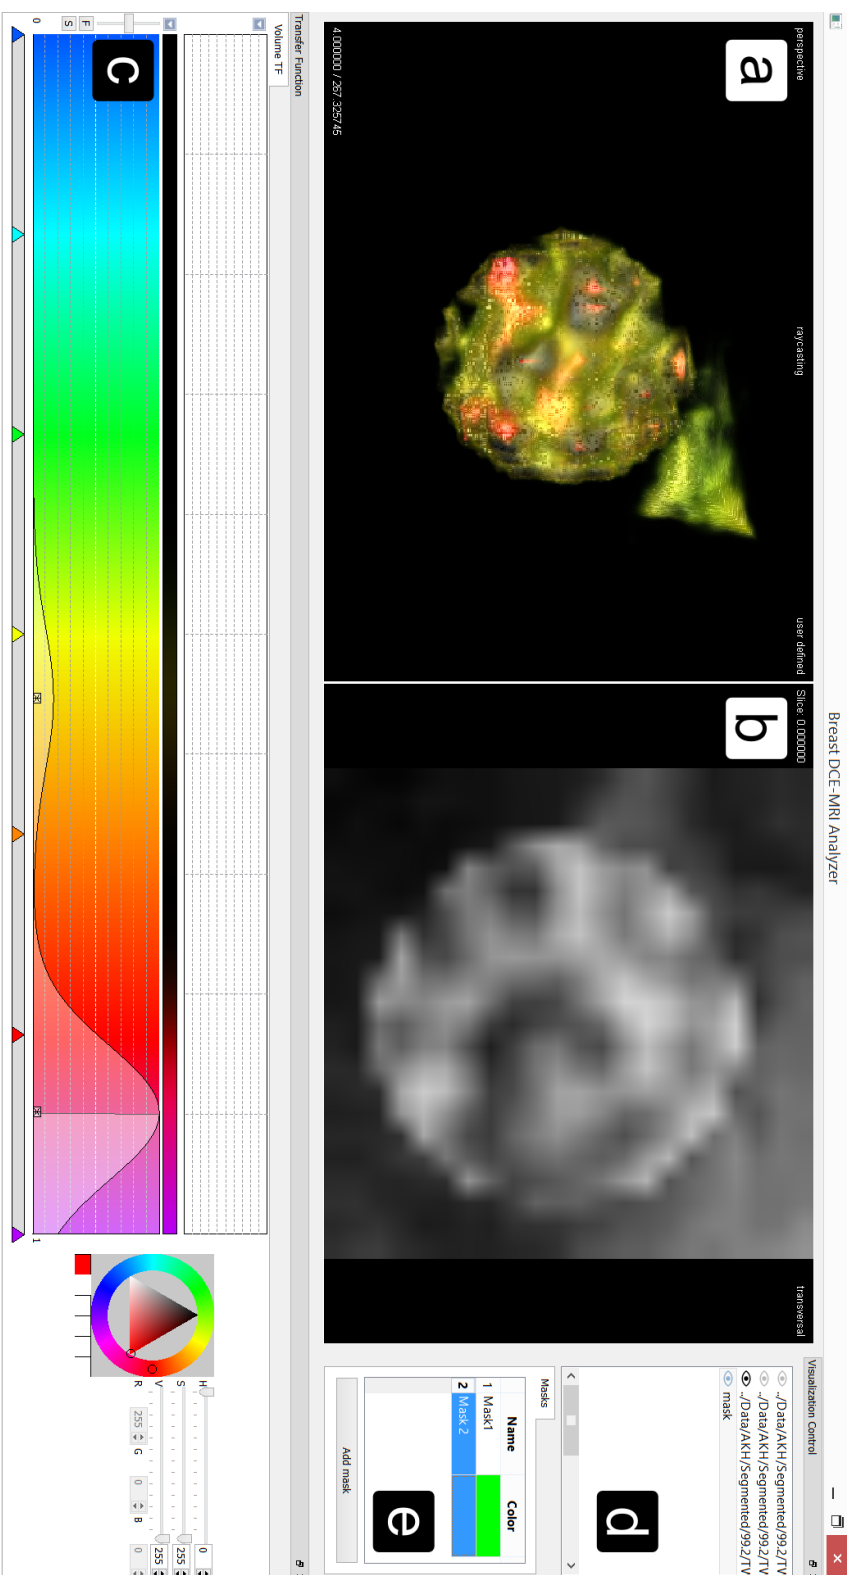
A screenshot of our software prototype, the *Breast DCE-MRI Analyzer*. (a) shows the 3D view, (b) shows the slice view. (c) shows the TF UI. (d) shows the volume data UI and (e) the mask UI.
